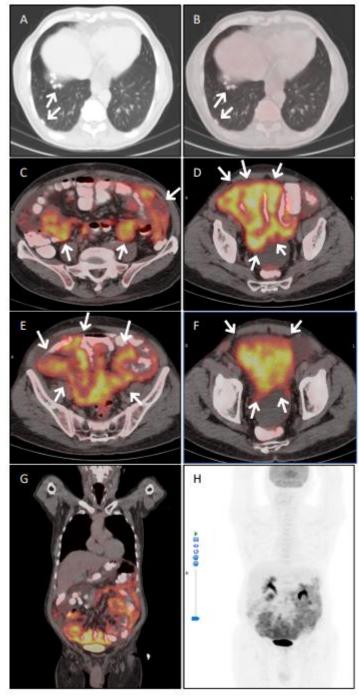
The axial CT and PET/CT images of the chest (A,B) show calcified nodules in the basal segments of the lower lobe of the right lung. The axial PET/CT images of the abdomen (C,D,E,F), coronal PET/CT image (G) and whole body maximum intensity projection (MIP) (H) demonstrated diffuse intense FDG uptake (SUVmax:6,9) on all intestinal serosal surfaces (white arrows)
